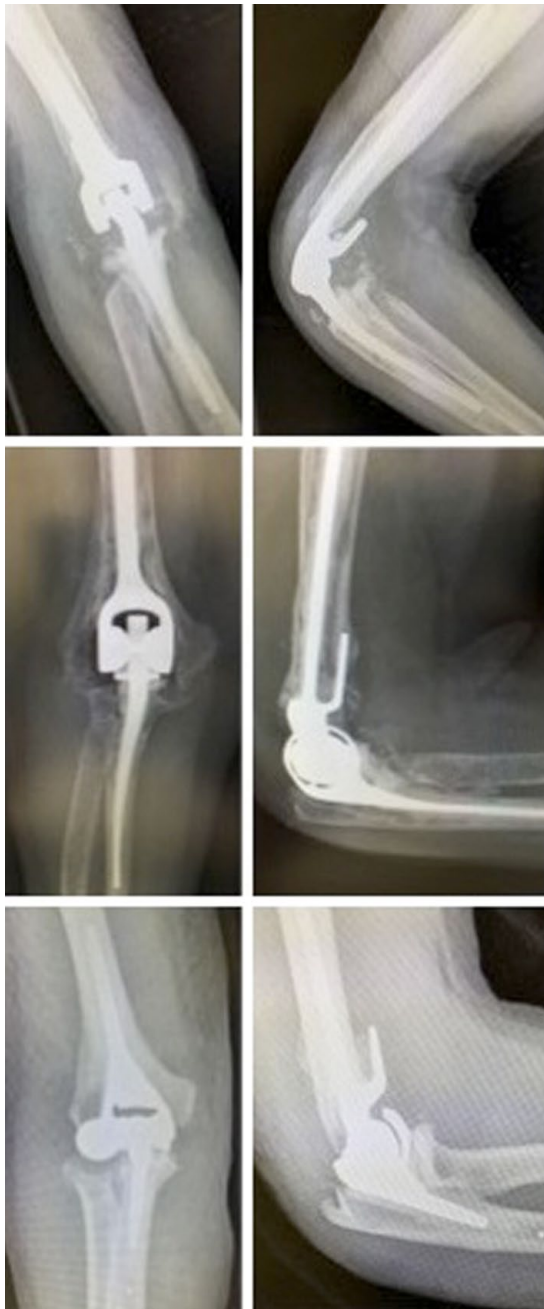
Radiographs presenting commonly used linked prostheses. From top to bottom: Coonrad-Morrey; Discovery; and Latitude.
